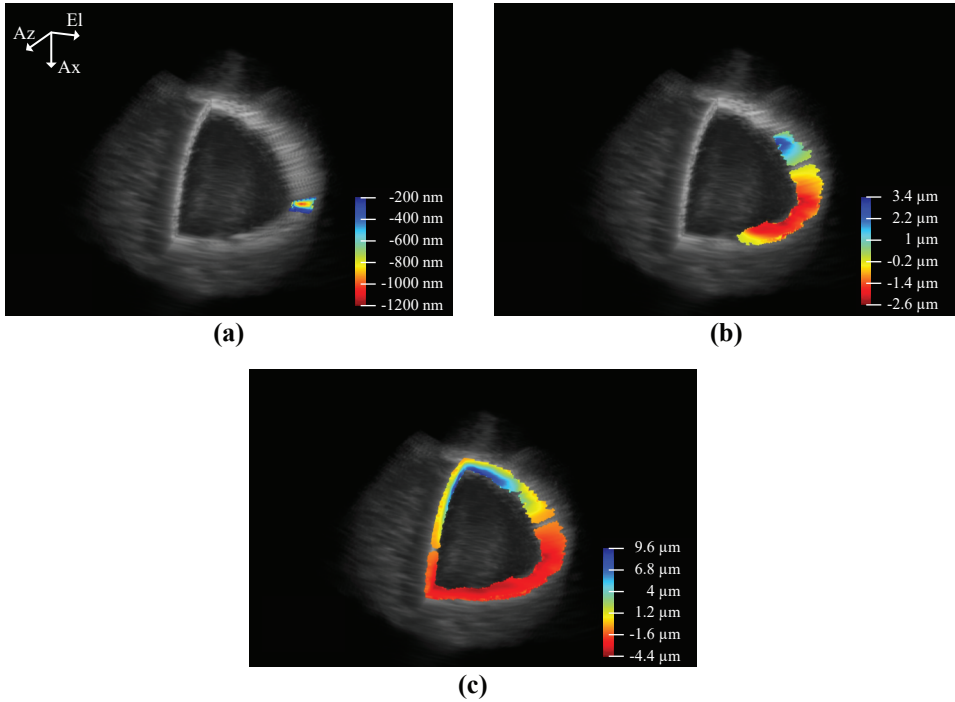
Tissue frame-to-frame axial displacement map corresponding to electromechanical wave propagation at (a) $t = 1$ ms, (b) $t = 11$ ms, and (c) $t = 21$ ms plotted on orthogonal planes. The blue arrow on (a) shows the initial point of EW and the red arrow on (c) shows the location at which the displacement is perpendicular to the ultrasound axial direction and cannot be estimated. The probe is located left side of the atrium at a 50-mm distance. Please note that the color scale represents axial displacement over 1ms, so a displacement of $10 \mu\text{m}$ is equivalent to an axial velocity component of 10 mm/s.
